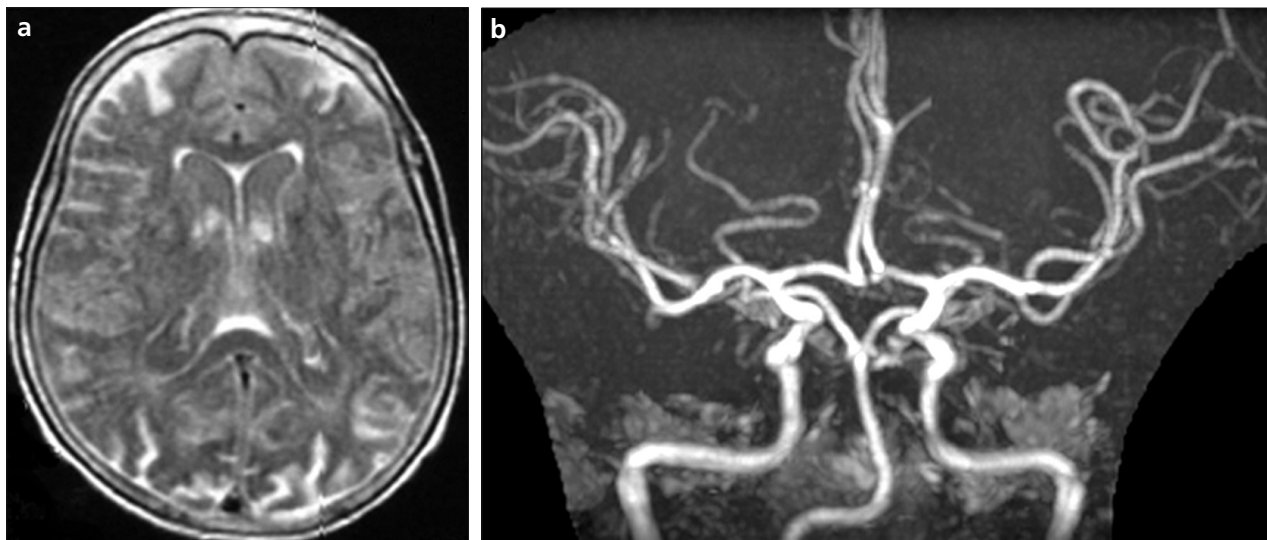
a, b. Axial FLAIR image (a) obtained three days after intravenous gadolinium administration demonstrates a significant, diffuse increased signal intensity within the subarachnoid space and the ventricles because of a delay in the clearance of the gadolinium chelate. The same-day MR angiography (b) was normal.
